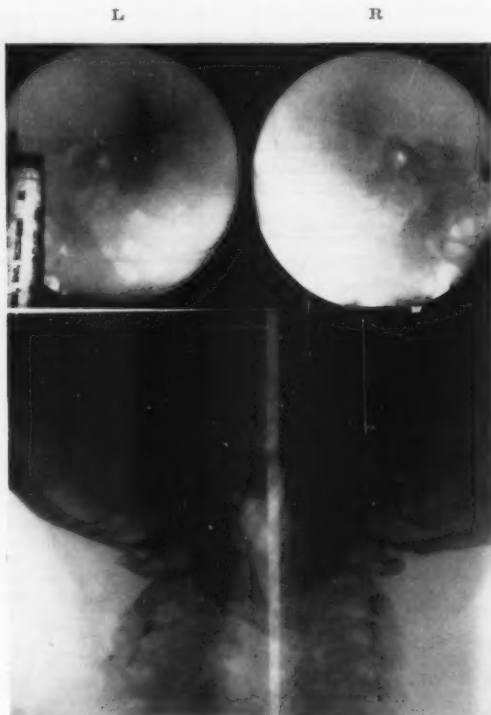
Roentgen plates of mastoids.
